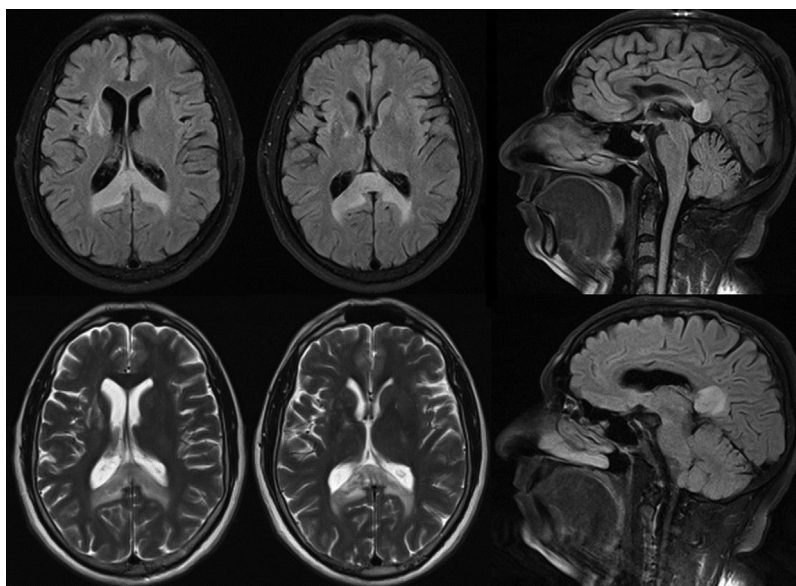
MRI of the brain showing a well-demarcated lesion involving the splenium of corpus callosum extending to the bilateral forceps major, characterized by the absence of a mass effect, low signal intensity on T1-weighted images, intermediate-high signal intensity on T2-weighted images, high signal intensity on FLAIR sequence and diffusion restriction.
